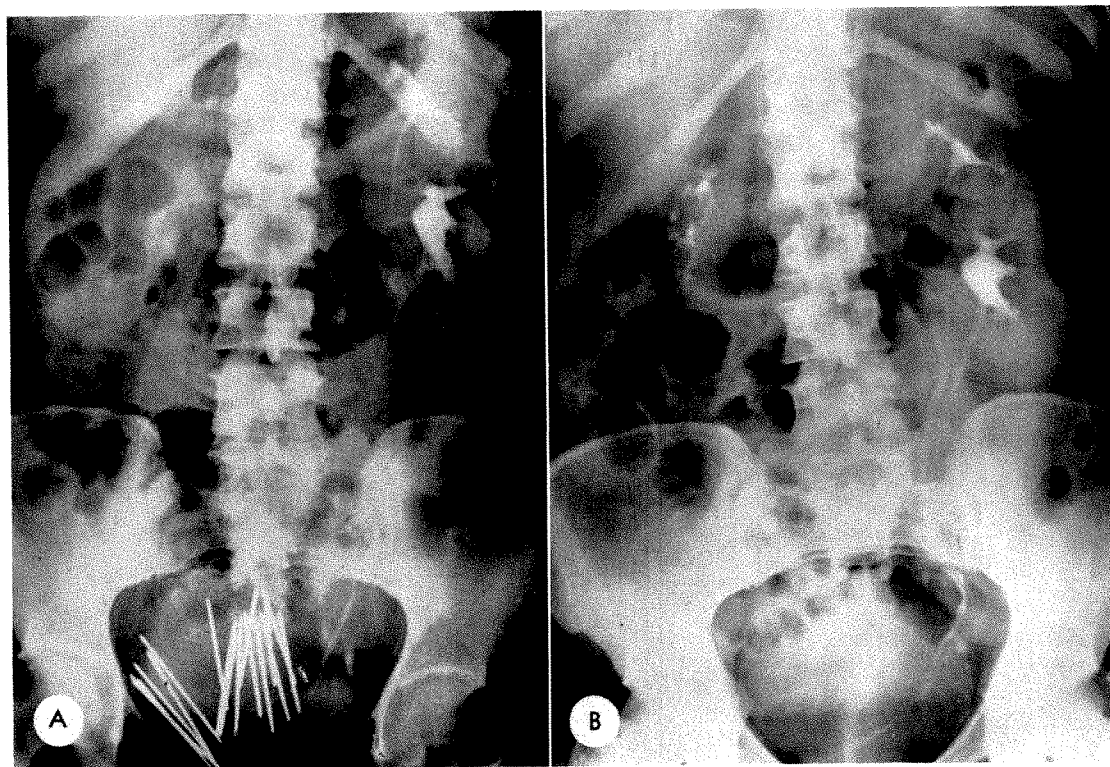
Case 1. (A) Nonvisualization of the right kidney pelvis and ureter due to ureteral obstruction secondary to malignant invasion of the right parametrium extending entirely to the pelvic wall. (B) Visualization of the normal right kidney pelvis 6 months after the implantation of low intensity radium needles in the cervix and right parametrium and the addition of a small amount of conventional roentgen therapy.
